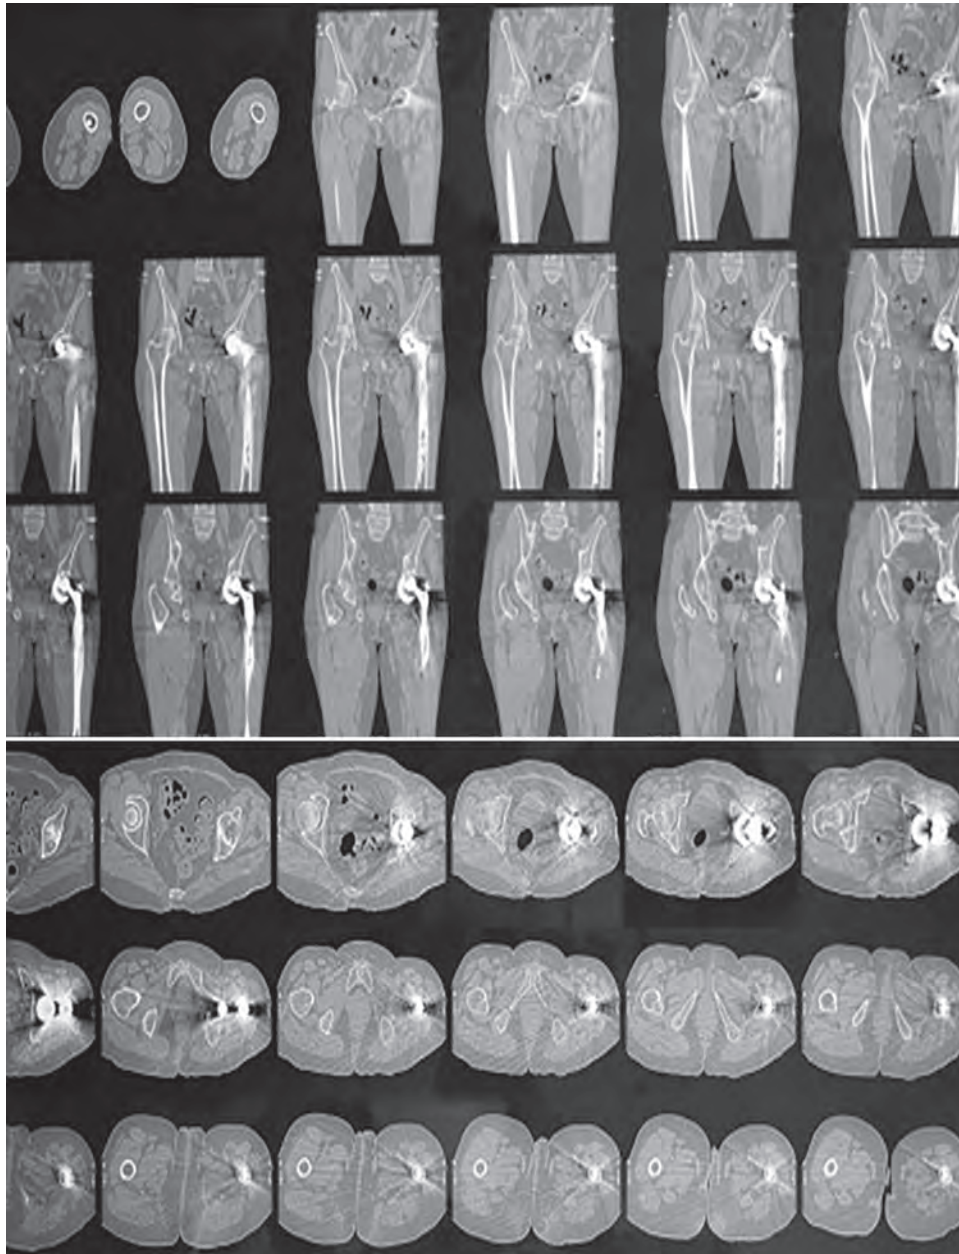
Preoperative CT scan
